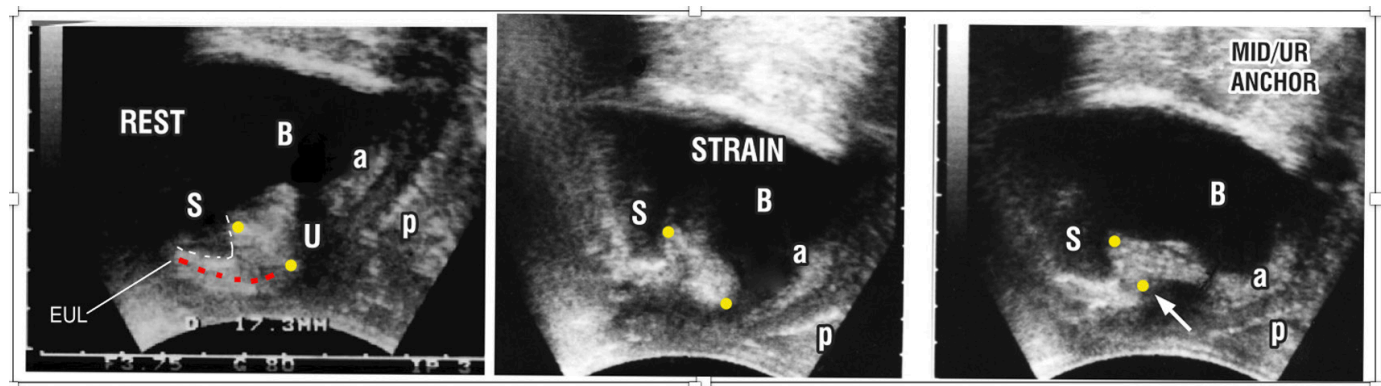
Transperineal ultrasound of a woman with stress urinary incontinence. (A) At rest, (B) during straining and (C) with a haemostat (white arrow) supporting the pubourethral ligament at midurethra. S, symphysis; U, urethra; B, bladder; a and p are the anterior and posterior walls of the vagina; the two yellow circles mark the length of pubourethral ligament extending from behind the lower border of the symphysis to the midurethra; red broken lines mark the anterior wall of the distal urethra. a, anterior wall of the vagina; B, bladder; EUL, external urethral ligament; p, posterior wall of the vagina; S, symphysis; U, urethra.
